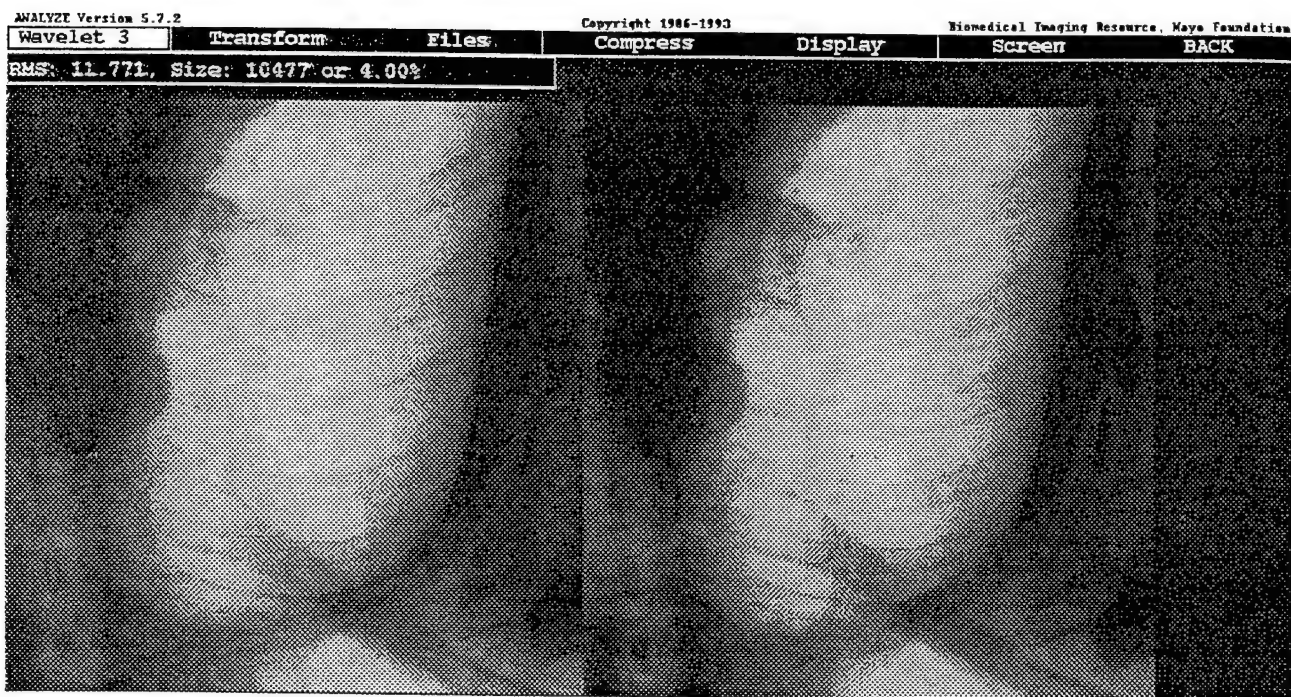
A portion of a chest X-ray and a compressed version at 4.0% of the original size.
